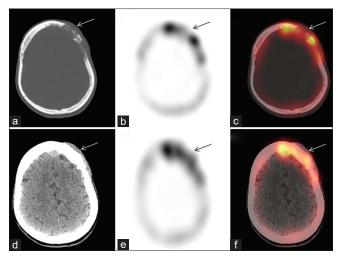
Transaxial CT (a and d), SPECT (b and e) and fused SPECT/CT images (c and f) of the skull. Increased tracer uptake is noted in the lytic erosive lesion involving the left frontal and parietal bones with soft-tissue component (arrows in a-f). SPECT/CT: Single-photon emission computed tomography with computed tomography
